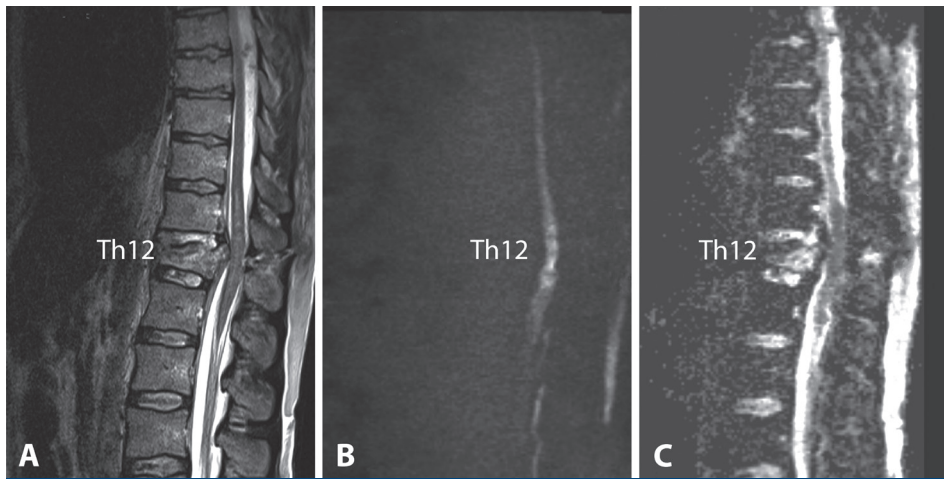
Images of case no. 7. (a) Sagittal T2-weighted imaging of an unstable fracture at the level of Th12 with a compression of the lower thoracic spinal cord. (b) There is a hyperintense lesion on the DW image. (c) The hyperintensity on the DW images is hypointense at the corresponding level on the ADC map.
